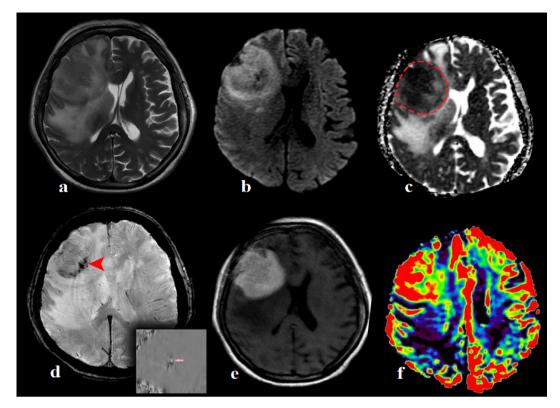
Patient B., 47 y.o., with primary central nervous lymphoma, after chemotherapy (4 cycles (21-day) – combination Rituximab 375 mg/m2 and Methotrexate 3.5 g/m2). In the right frontal lobe, there is a superficial intracerebral formation without cortical involvement with extensive vasogenic edema on T2 (a). The diffusion restriction is uneven, most pronounced in the central regions as a high signal in DWI b = 1000 (b) and a low, almost black signal on the ADC map (c, inside the dotted red circle). On SWI the mass has hemorrhages (d, red arrow), the presence of hemosiderin is confirmed by reconstruction of phase images as black poles (pink arrow). The lesion shows intense and homogeneous contrast enhancement typical of lymphomas on post-contrast T1 image (e), increased tumor blood volume values with perfusion (f).
